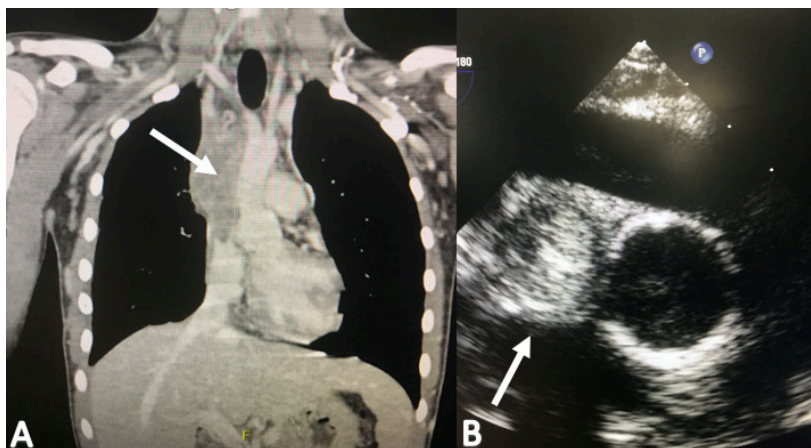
(A) Computed tomography angiography showing thrombosis of the superior vena cava (arrow). (B) Transesophageal echocardiogram images showing 90% occlusion of the superior vena cava circumference (arrow).
